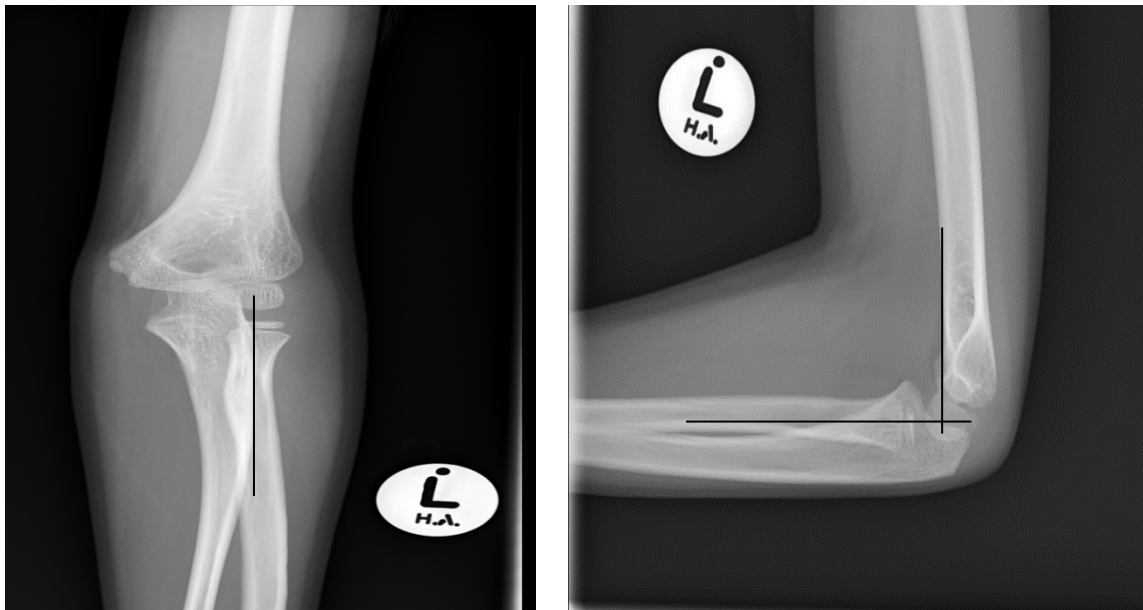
AP and lateral radiograph of a normal elbow
